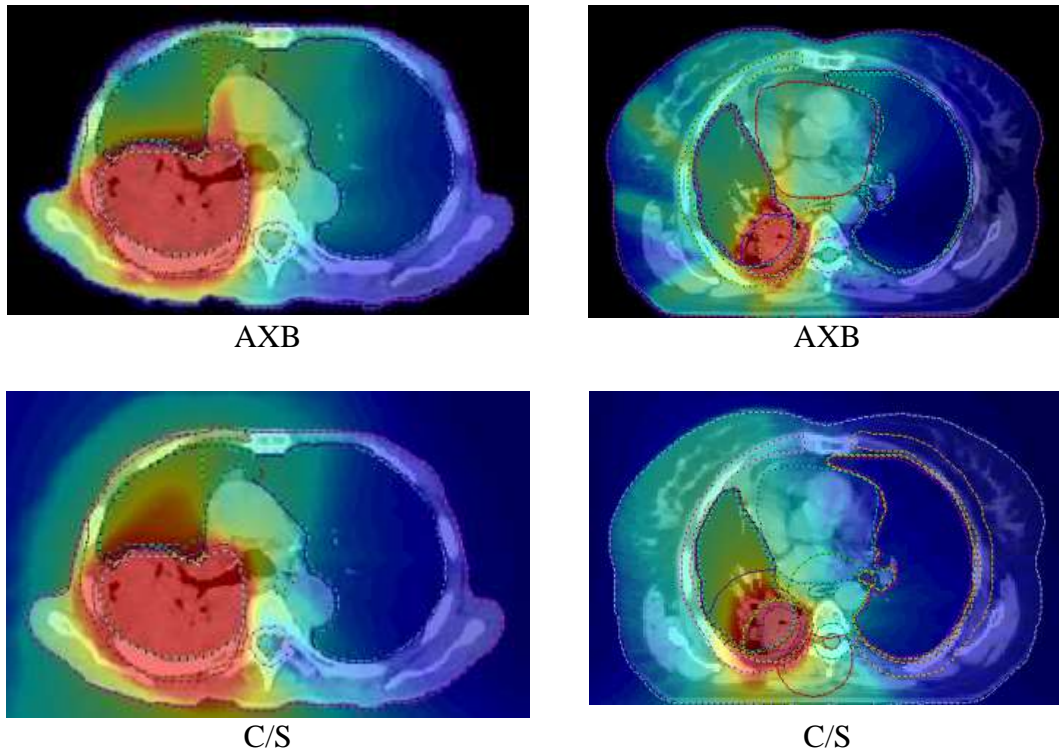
Dose distribution images of two different volumes in the same CT Slices.
